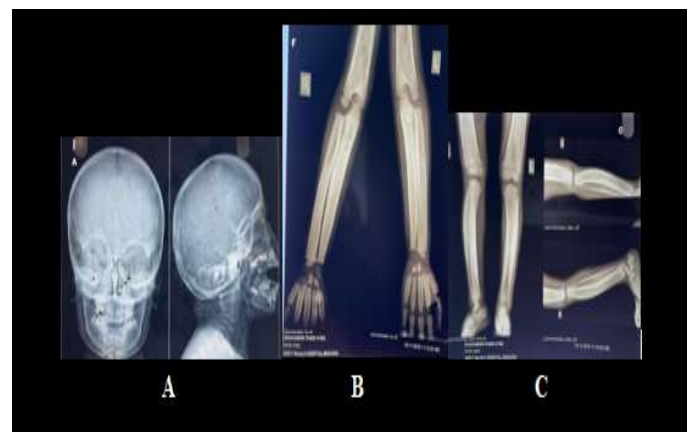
The radiographical report X-ray images showing features of Camurati-Engelmann disease in the patient at presentation (A) Frontal radiograph of the skull shows sclerosis and cortical calvaria and the Lateral radiograph of the skull shows sclerosis and thickening of the skull base and mandible, (B), the x-ray of the right-hand shows the sclerotic changes in the diaphyses, Similar changes were observed in the left hand, (C) Thickening and irregularity of endosteal and periosteal sides of diaphyses of all long bones of Tibia, fibula, and femur.
